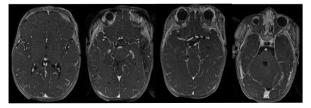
Brain magnetic resonance imaging (MRI) with injection showing a decrease in the size of the left palpebro-orbital angioma
